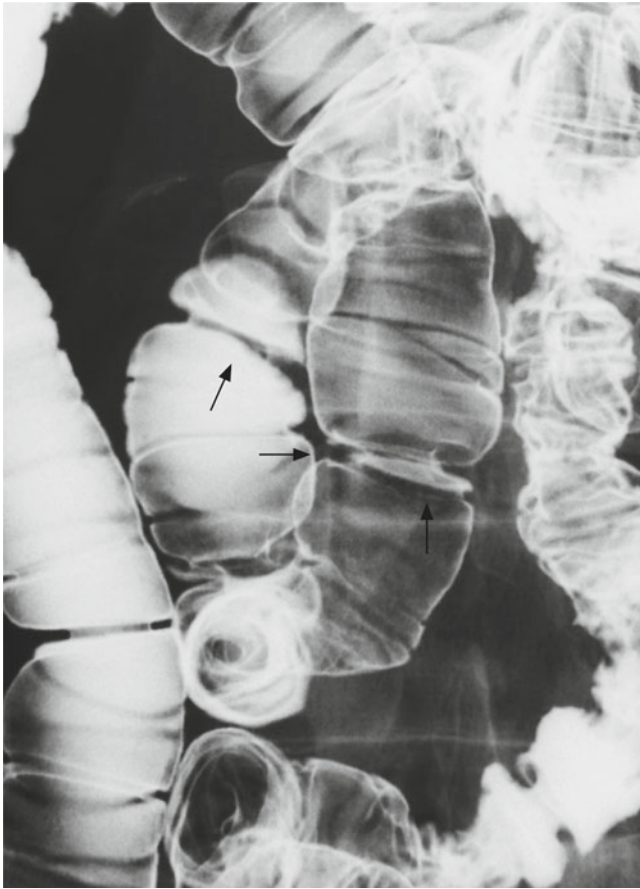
Radiography performed at almost the same time as CE showed bilateral stenosis from the jejunum to the ileum, irregular Kerckring's folds, indentations, and circular ulcers (*arrows*)
